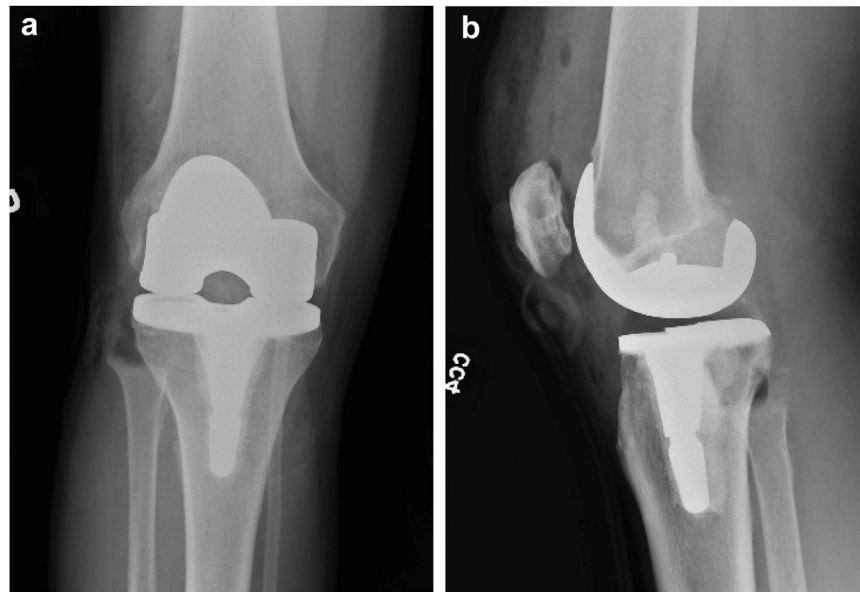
(a) Anteroposterior and (b) lateral plain radiographs of the knee immediately postoperatively.
